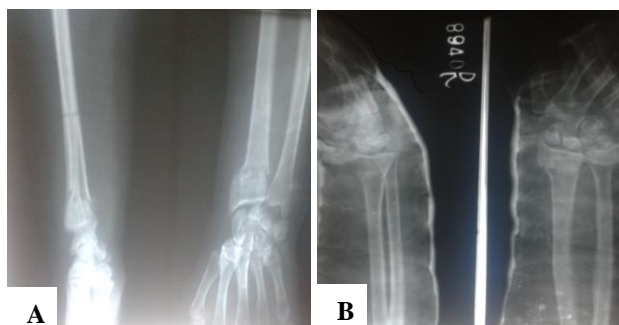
A) X-ray before Colles cast application; B) X-ray after Colles cast application.
